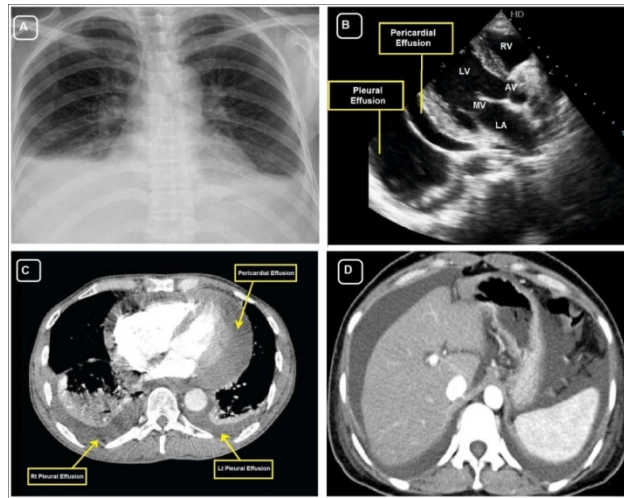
Chest x-ray revealed pleural effusion and pericardial effusion (figure-1A). which were confirmed by 2D echo (figure-1B) and CT chest (figure-1C), followed by CT abdomen (figure-1D) revealed ascites without any mass or lesion .
